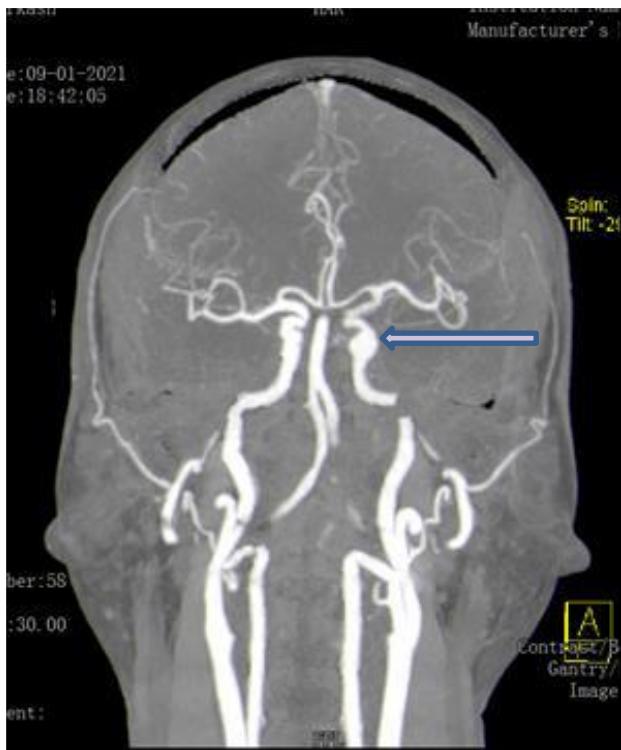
CT angiogram depicting fusiform mycotic aneurysm in the cavernous segment of left ICH (arrow).
